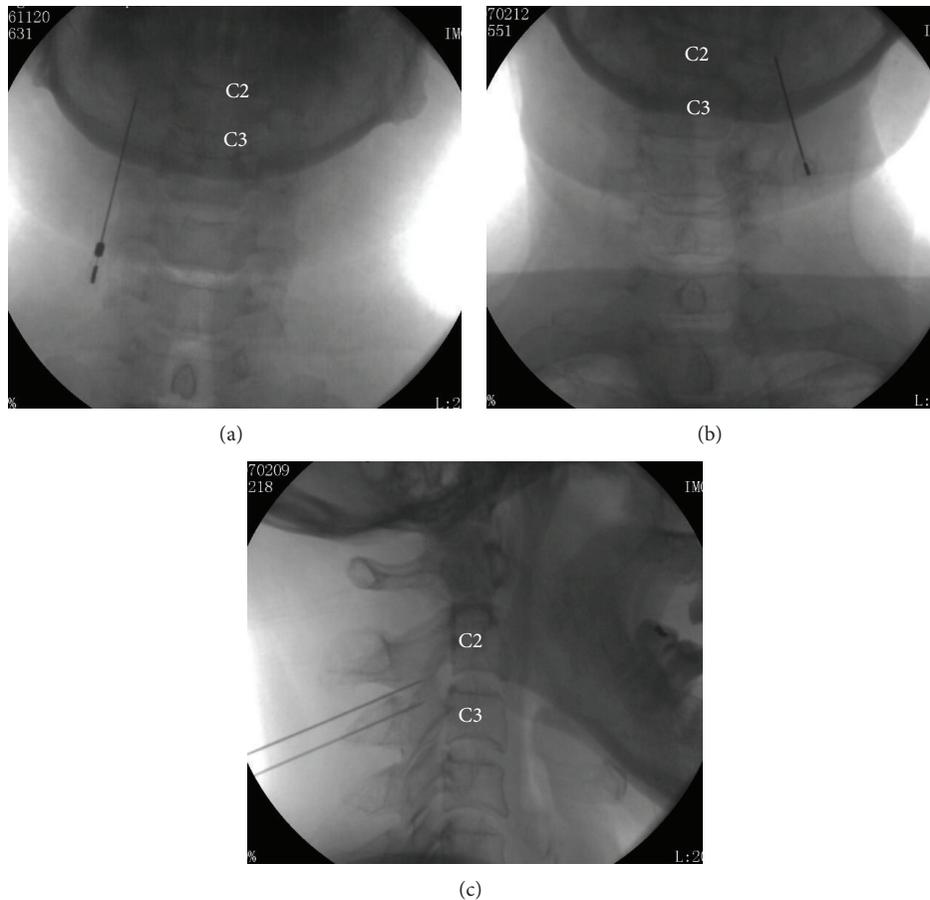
X-ray photos in the PRF treatments. ((a) and (b)) The C-arm machine was placed in the anteroposterior position and the puncture points were at the C2 level. (c) The C-arm machine was placed in the lateral position. The tip of the needles reached the medial branch of C3 and third ONs (C3 and C2, resp.).
